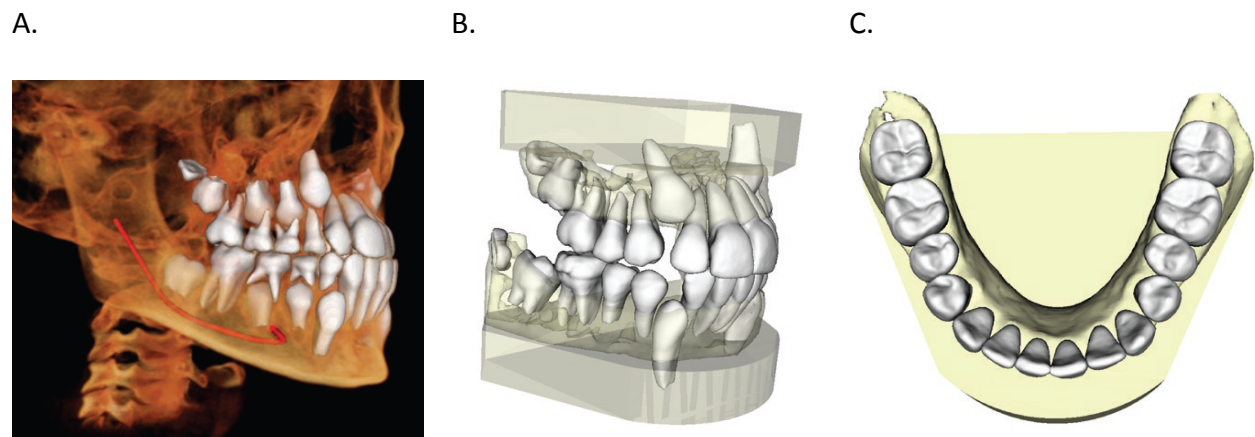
Images from InVivoDental software: (A) A patient's CBCT volumetric scan, (B) Study models permitting visualization of roots and unerupted teeth, (C) Occlusal view of mandibular dental arch.
